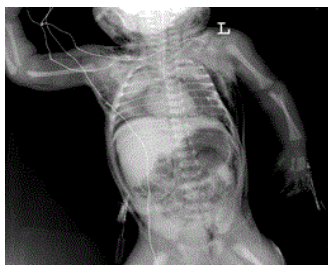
Supine chest radiograph showing spontaneous pneumomediastinum. Gas outlined and elevated the thymus gland, leading to “spinnaker sail sign” (arrowheads). Bilateral pneumothorax was present (short white arrow). Pneumopericardium was noted as single band of gas surrounding the left ventricle (long white arrow). Pneumoperitoneum (short black arrow) and subcutaneous emphysema (long black arrow) in the neck and chest extending from the mediastinum developed secondary to a large amount of mediastinal air.
